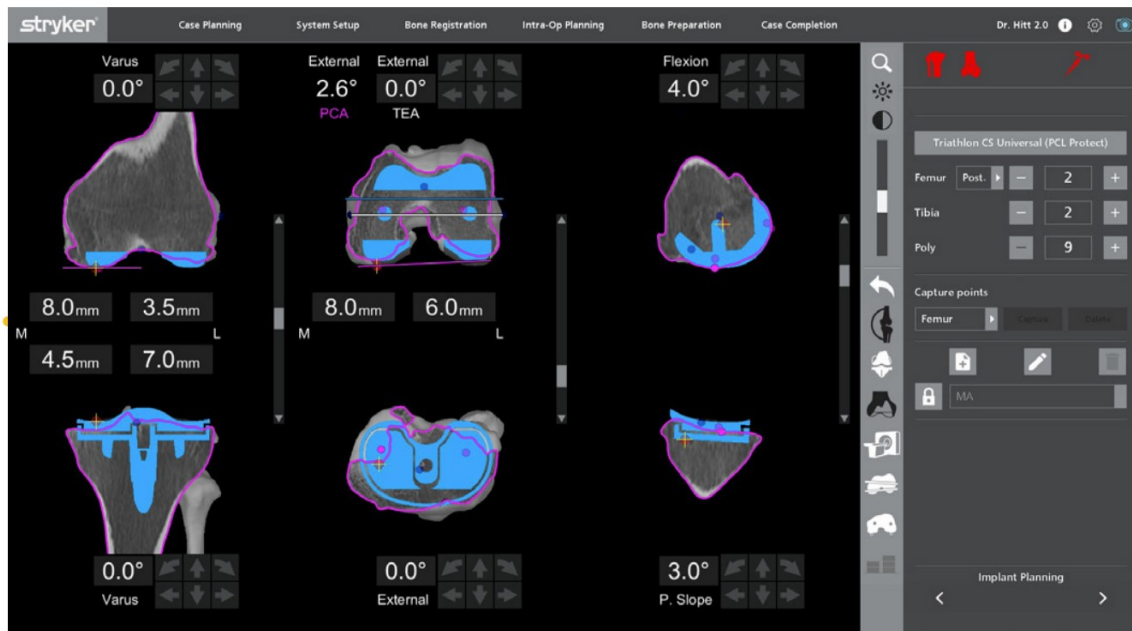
Mako Total Knee 2.0 3D CT-based pre-planning [2].
